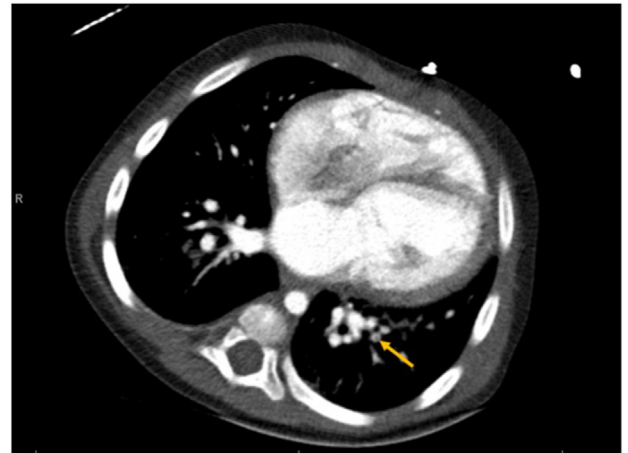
Contrast-enhanced CT of the chest, axial display, demonstrates biventricular dilation and a filling defect in the RA and in the subsegmental left lower lobe pulmonary artery branch (arrow).
